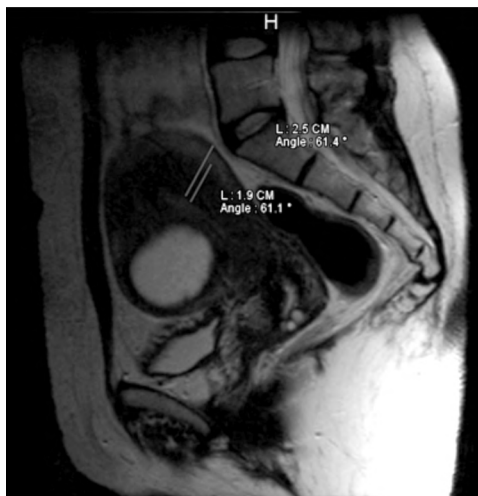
Female patient 49 years old, presented by lower abdominal pain not responding to medical treatment, had clinical ultrasound features suggesting uterine adenomyosis, image (F) that showed revealed bulky RUV uterus with globular contour, heterogeneous texture, asymmetrical wall thickness, small myometrial cyst as well as anterior wall heterogeneous ill defined area mimicking myoma, MRI was done (A-E) showed bulky RUV uterus of globular shape (A), significant increase of JZ and JZ/myometrial thickness ratio (measures) with, multiple hyper intense myometrial small or micro cysts (A, B) not suppressed on T2 fat suppression image (D) and few of the cyst noted hyper intense in T1 WI black arrow (C). Ill defined anterior wall hypo intense lesion has hyper intense micro cysts with protrusion of the lesion with its microcysts into the endometrium (A, B, D). Hyper intense striations extending from the endometrium to myometrium (E) with endometrial invagination at lower posterior wall (arrow) (A).
